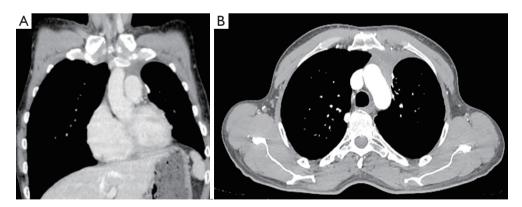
Coronal CT (A) and axial CT (B) images show the absence of disease relapse during follow-up. CT, computed-tomography.
